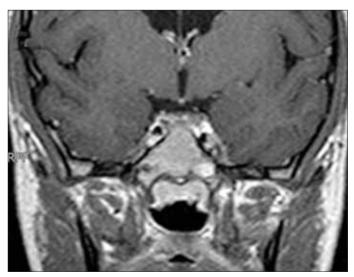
MRI scans were revealing cavernous sinus left side enlargement and tumor extension
